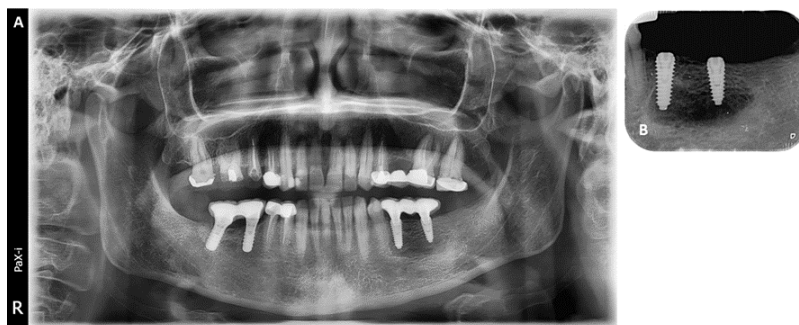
Radiographic examination following the implant placement: (A) Orthopantomogram showing implants and fixed crowns, (B) Periapical image showing the implants placement.
